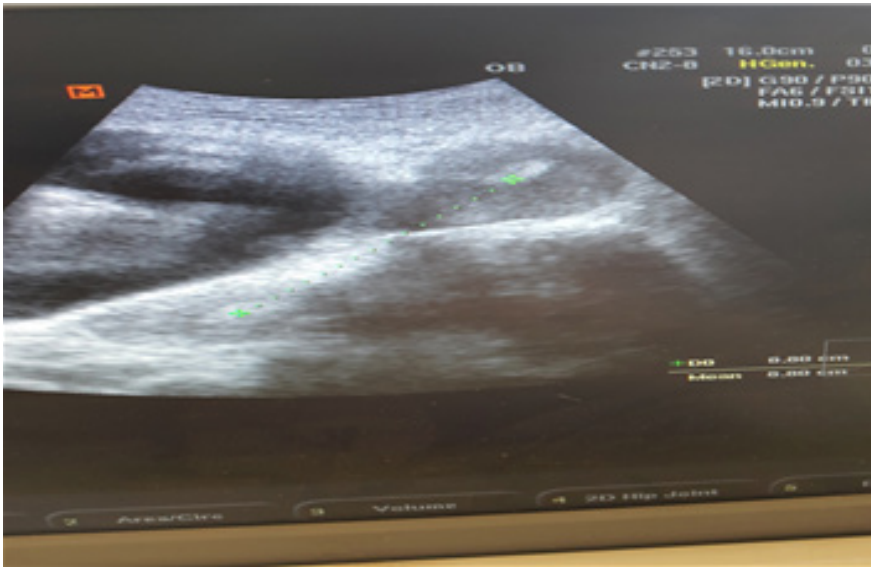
Ultrasonographic image showing the widely separated uterine horns.
